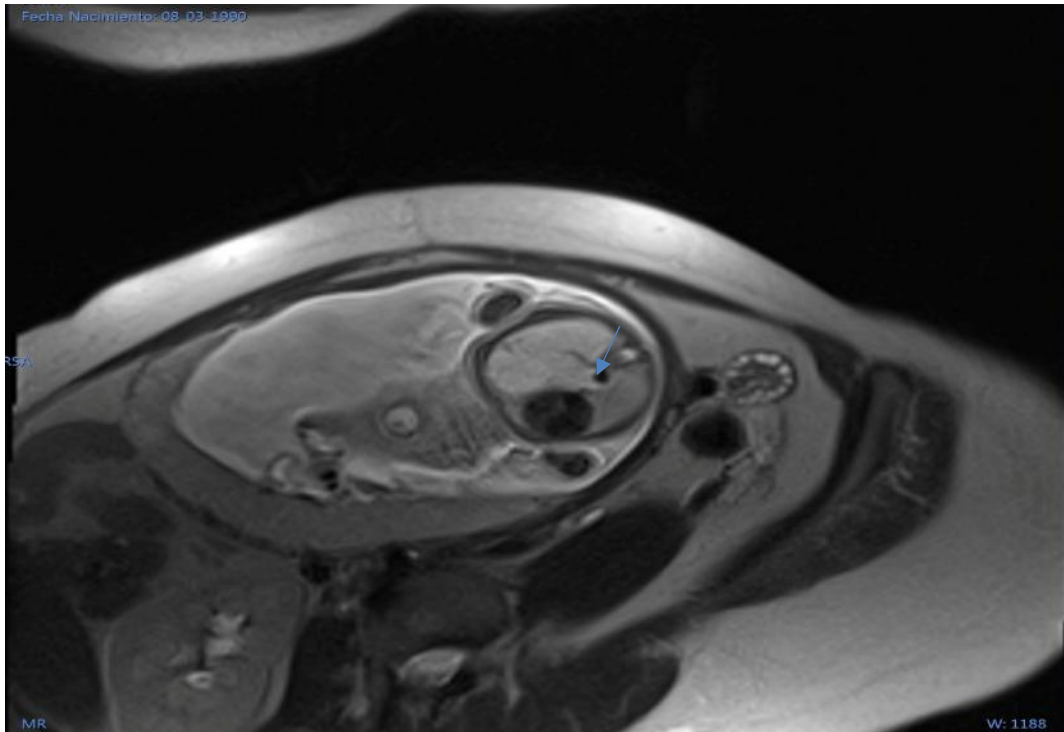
Prenatal MRI at 25 weeks, enhanced in T2, axial plane: in which hyperintense image is observed depending on the right lung and the arterial branch that supplies it with origin of the abdominal aorta (date).
